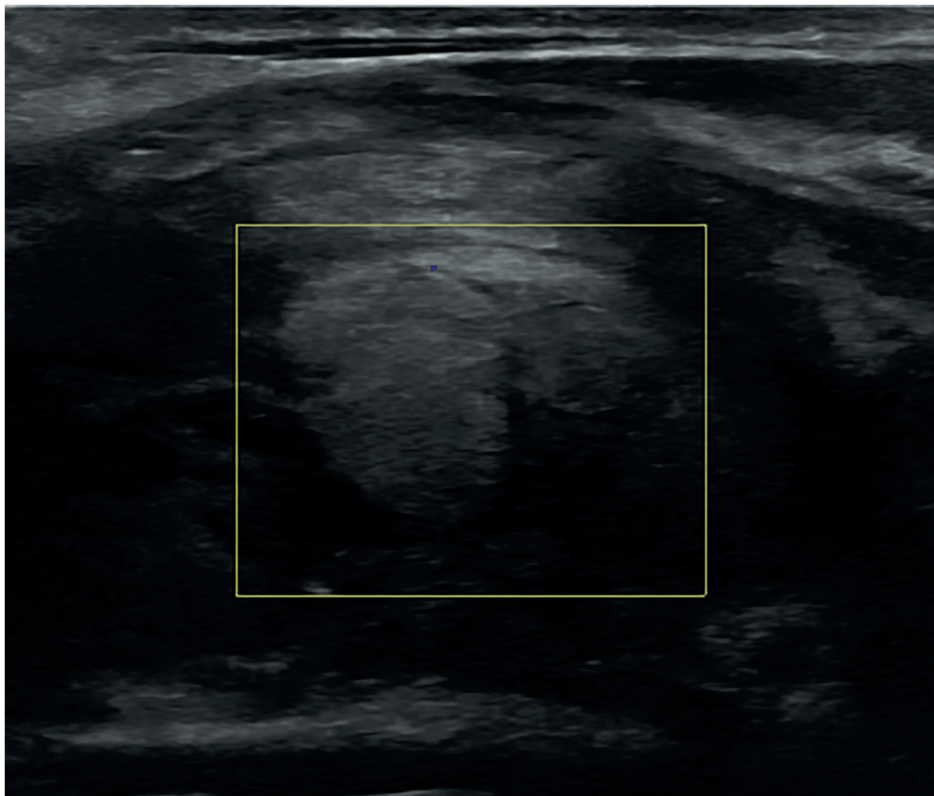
Color-coded Doppler sonography of the right thyroid lobe at initial presentation of the patient (sagittal axis). Figure originally published in Trummer et al. [2] under the CC BY license.
